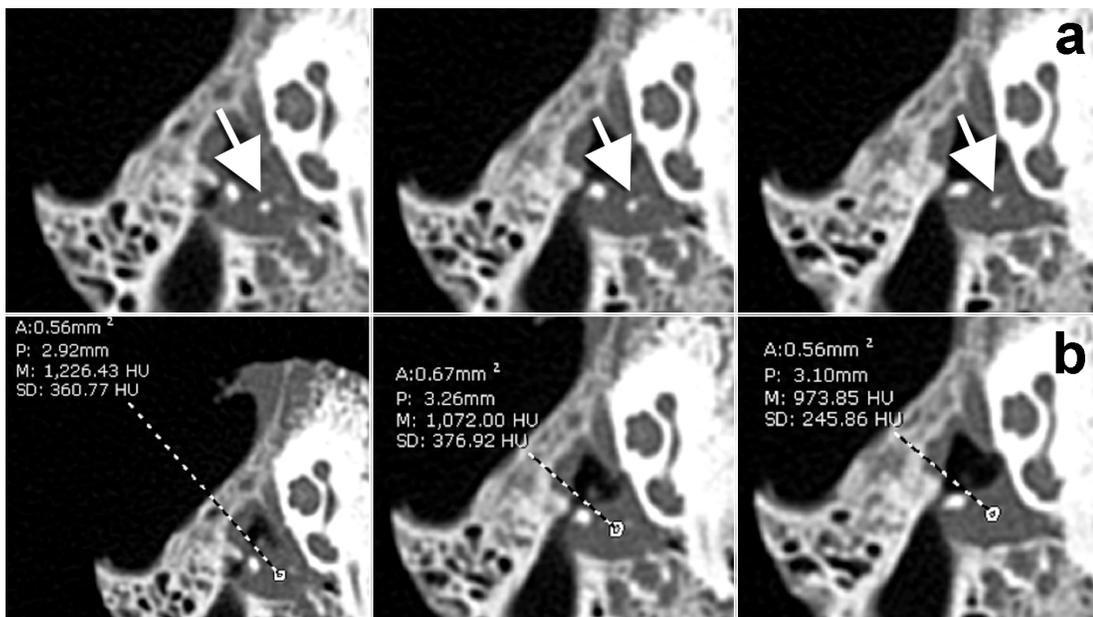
Axial CT images (a) with density measurements (b) of three contiguous images through the distal long process of the right incus (arrow).
